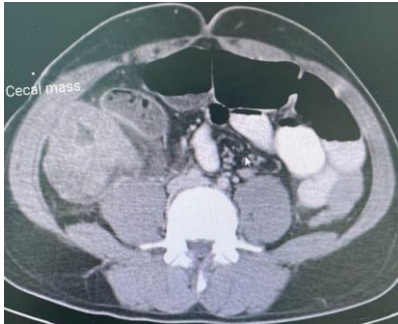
CT showing fungal ileocecal
